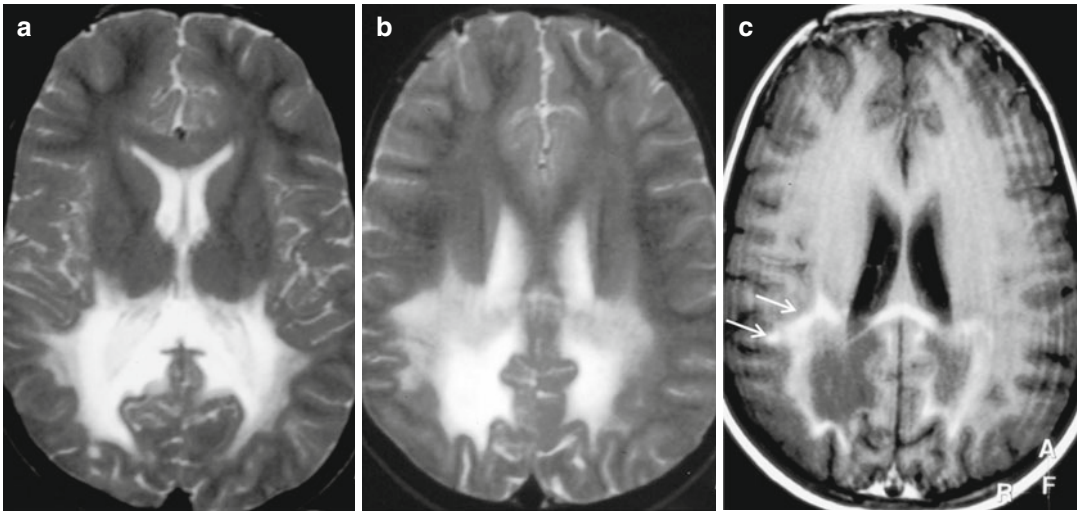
Cerebral form of X-linked adrenoleukodystrophy, c-ALD. MRI axial T2-weighted images (a, b) show marked bilateral symmetrical hyperintensity in the splenium
